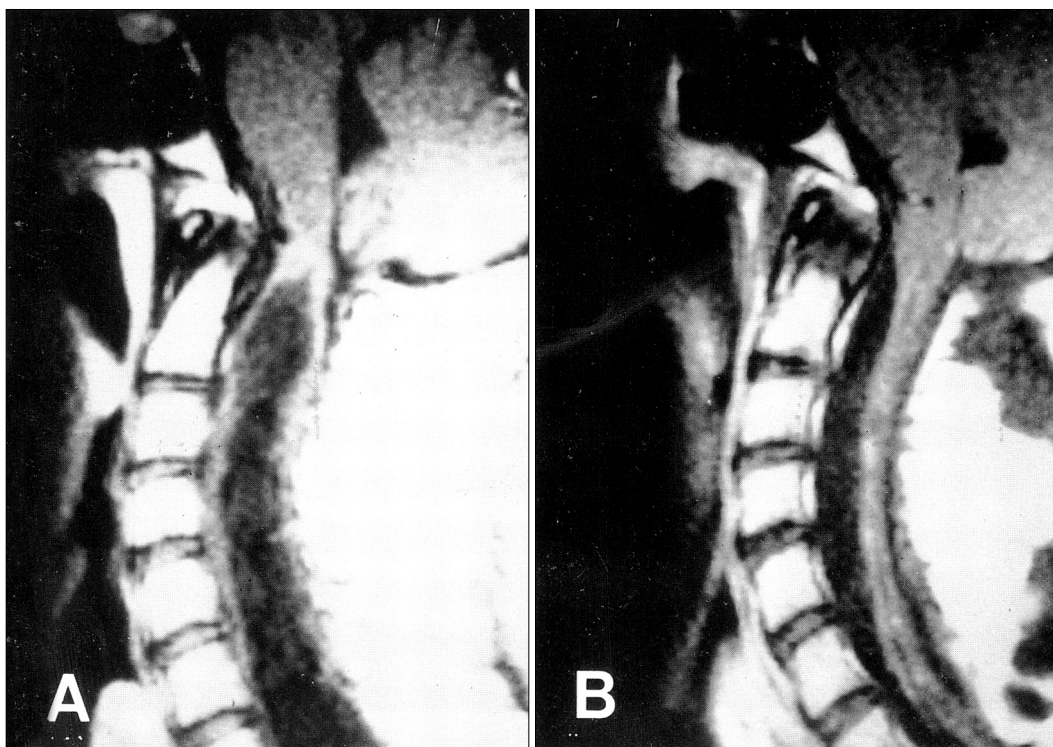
Magnetic resonance image of cervical region preoperatively(A) and 14 days(B) after suboccipital decompression with duro-plasty. Progressive collapse of the cervical syrinx is noted.
